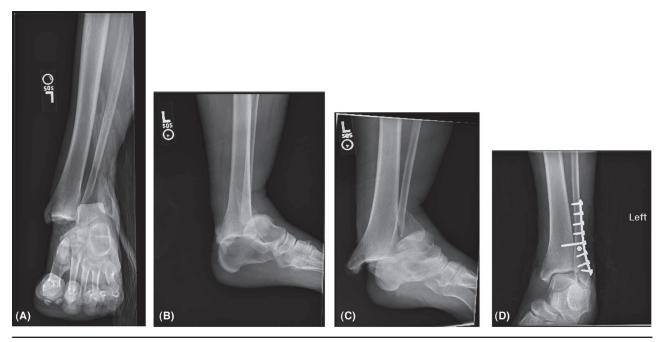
Syndesmotic diastasis associated with proximal and distal fibular fracture. Views A, B, and C of the X-rays demonstrate syndesmotic disruption, fibular fracture, severe ankle dislocation, and rupture of the Deltoid ligament complex. View D shows post-operative ORIF (open reduction internal fixation) X-ray of the ankle following stabilization for severe ankle fracture dislocation.
